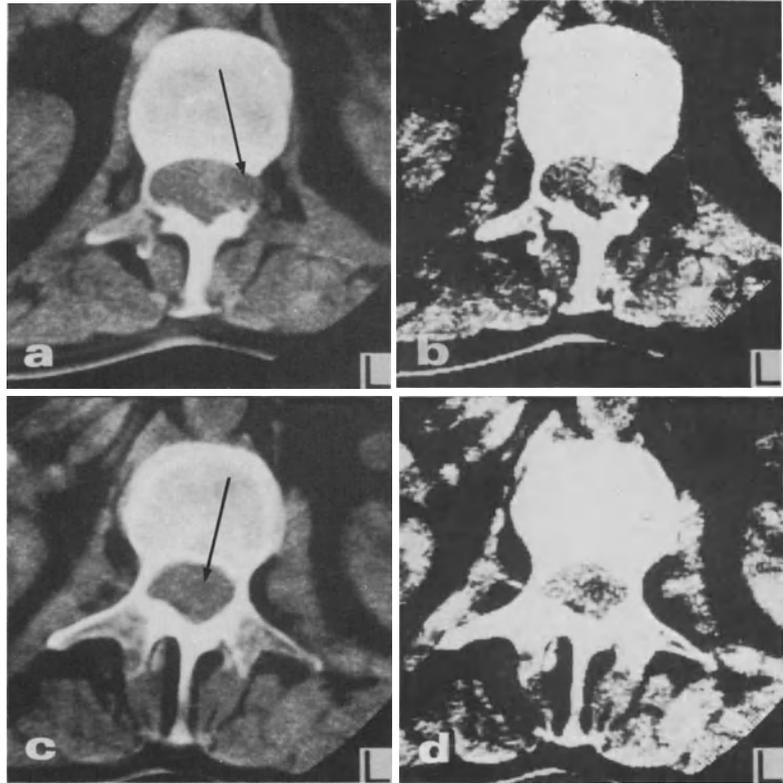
a-d. Intramedullary tumor location: Ependymoma of conus medullaris (CT scans without contrast enhancement). a, b Scan at the level of L 1, at low and high contrast window setting respectively, showing widened spinal canal with excavation of vertebral body and marked thinning of pedicles; inhomogeneous appearance of intraspinal soft tissues, area of low density medial to extremely thin left pedicle (a, *arrow*) probably representing tumor cyst. c, d Scan at level of L 2, at low and high contrast window setting respectively, showing less thinning of pedicles and less widening of spinal canal; area of low density in center of intraspinal soft tissues (c, *arrow*) probably representing additional tumor cyst
